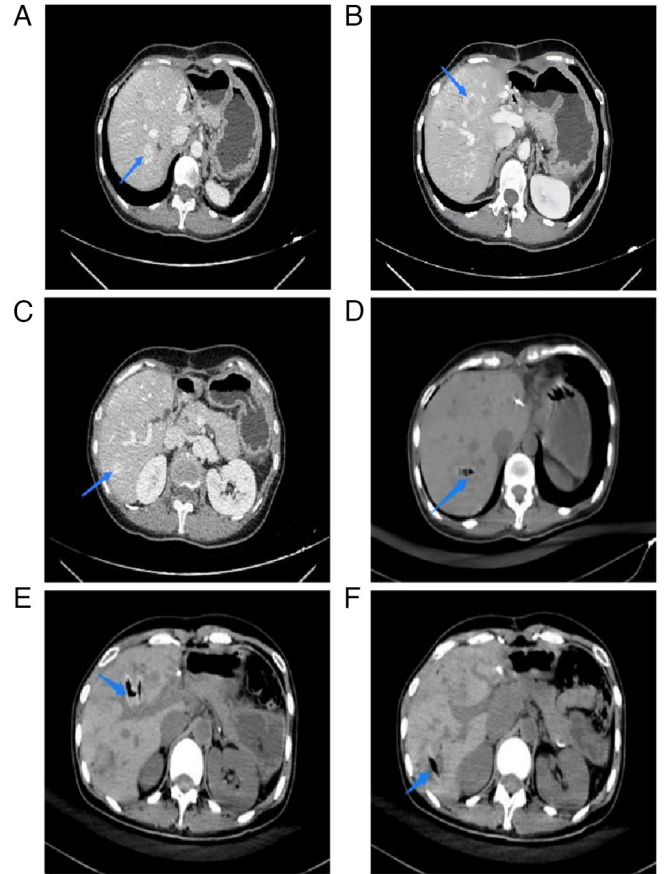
CT (enhanced) acquired at postoperative month 6. CT images (A-C) before and (D-F) after radiofrequency ablation of residual liver metastases. CT, computed tomography (the arrow indicates the liver metastasis lesion location).
